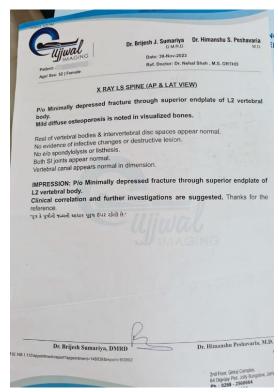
Xray- LS spine (AP and Lat view) on 30-Nov-2023
